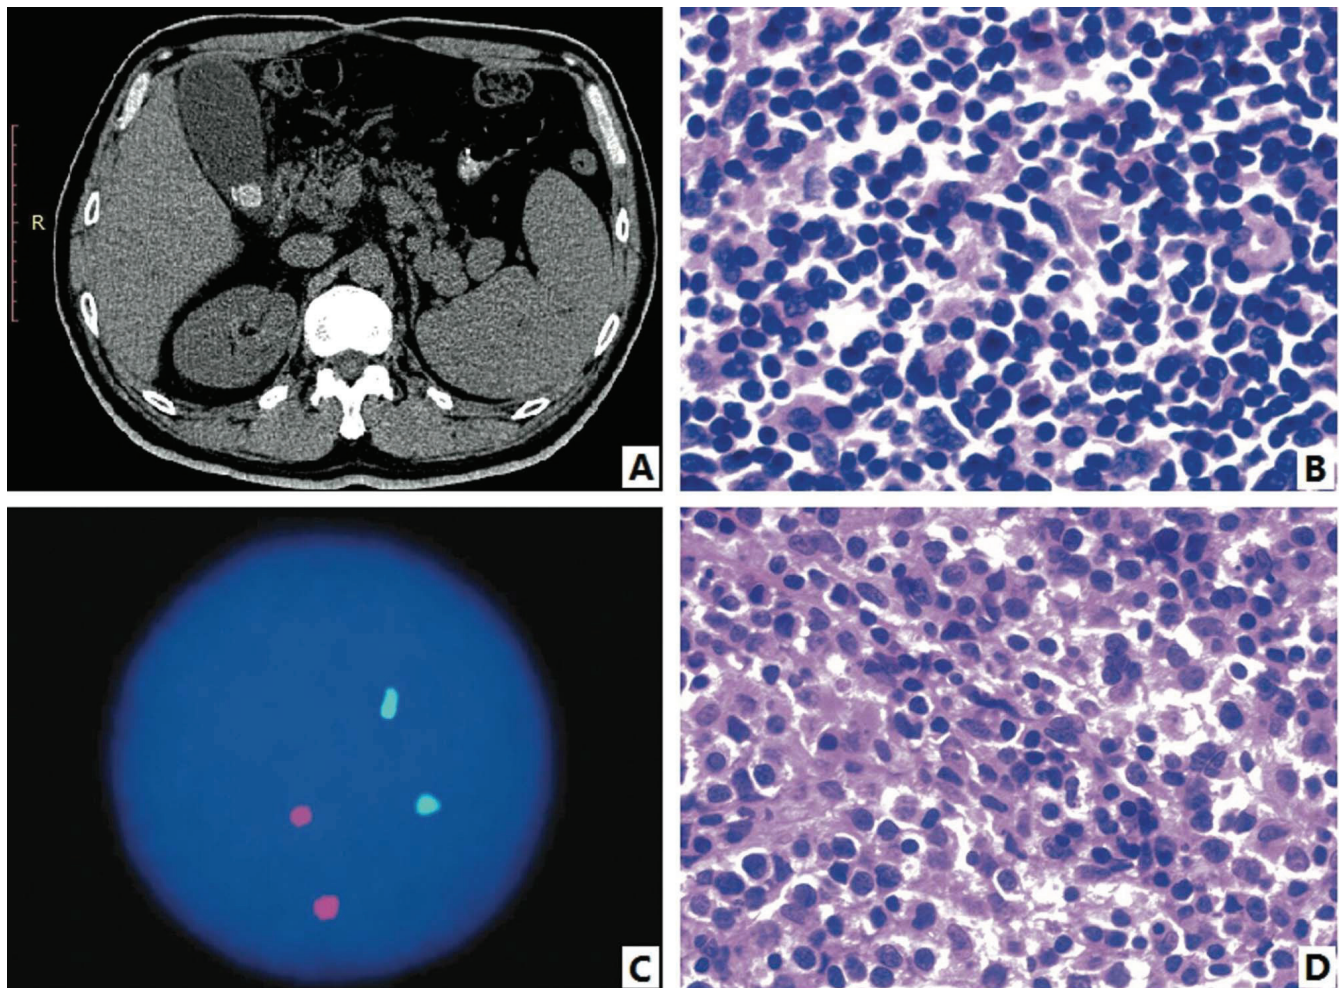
Diagnosis of mantle cell lymphoma. A. Abdominal computed tomography (CT) in May 2014; B. Result of the pathological biopsy in May 2014; C. Immunoglobulin H (IgH) and T-cell receptor gene rearrangements were negative; D. Result of the pathological biopsy in February 2017
